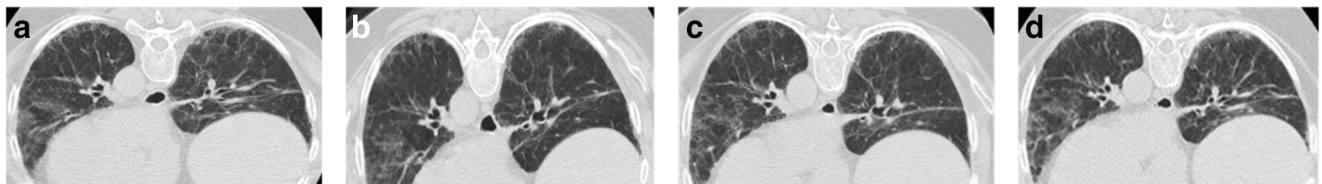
A stable case by PFT for 18 months from validation set: a–d a 65-year-old female with a whole-lung QLF score of 12% at baseline and no changes for 18 months; (a) baseline, (b) 6 months, (c) 1 year, and (d) 1.5 years of follow-up HRCT scans
